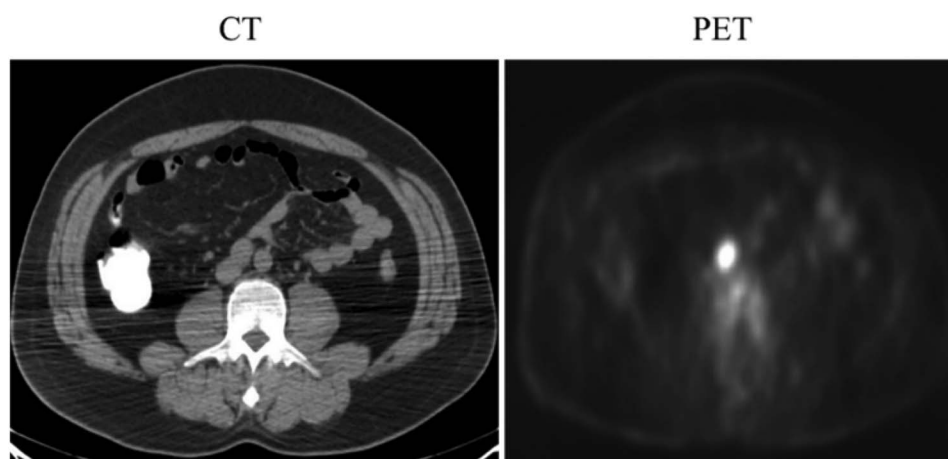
CT scan showing a single enlarged retroperitoneal lymph node in a patient with seminoma and corresponding positron emission tomography (PET) scan showing enhancement. Surgical pathology was consistent with metastatic seminoma.
